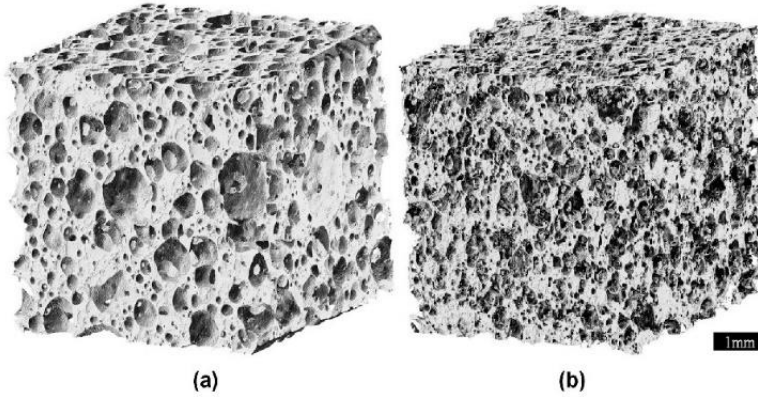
A 3-D reconstruction of a micro-computed tomography scan of a  $5 \times 5 \times 5 \text{ mm}^3$  cubic volume: (a) 0D-CPF; (b) 2D-CPF.
